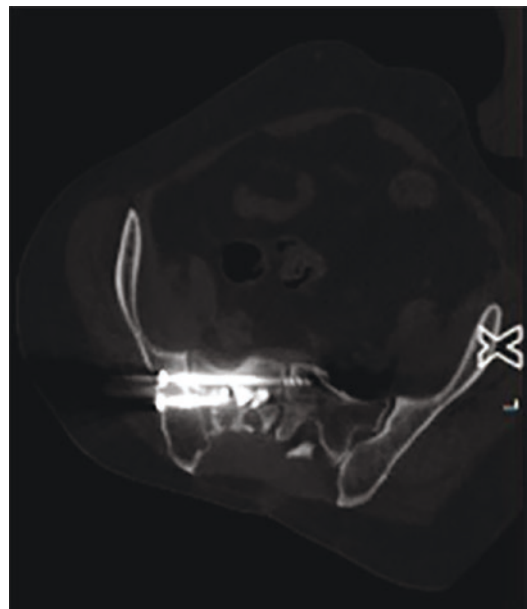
A sarcoma male patient with residual tumor and a pathological fracture post-surgery and radiotherapy. The patient was treated with percutaneous microwave ablation combined to augment sacroplasty with cement injection and placement of two cannulated screws. Computed tomography axial reconstruction shows the cement and the cannulated screws in position
